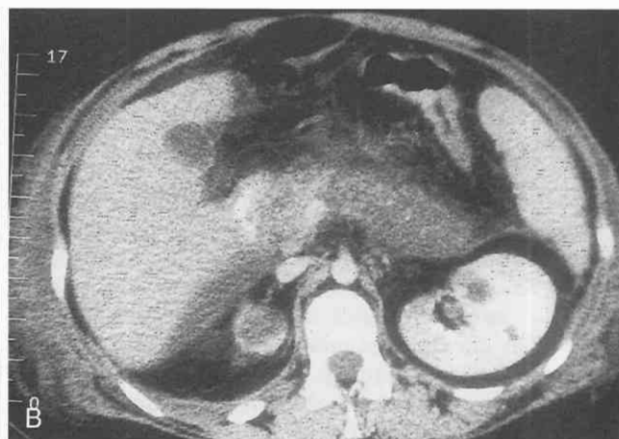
Acute pancreatitis with pancreatic necrosis. A, CT scan through the pancreas in a patient with acute pancreatitis demonstrates a normal-appearing pancreas. B, Follow-up CT scan through the pancreas 48 hours later after clinical deterioration shows the absence of parenchymal enhancement in the body and tail of the pancreas, indicative of areas of pancreatic necrosis.
